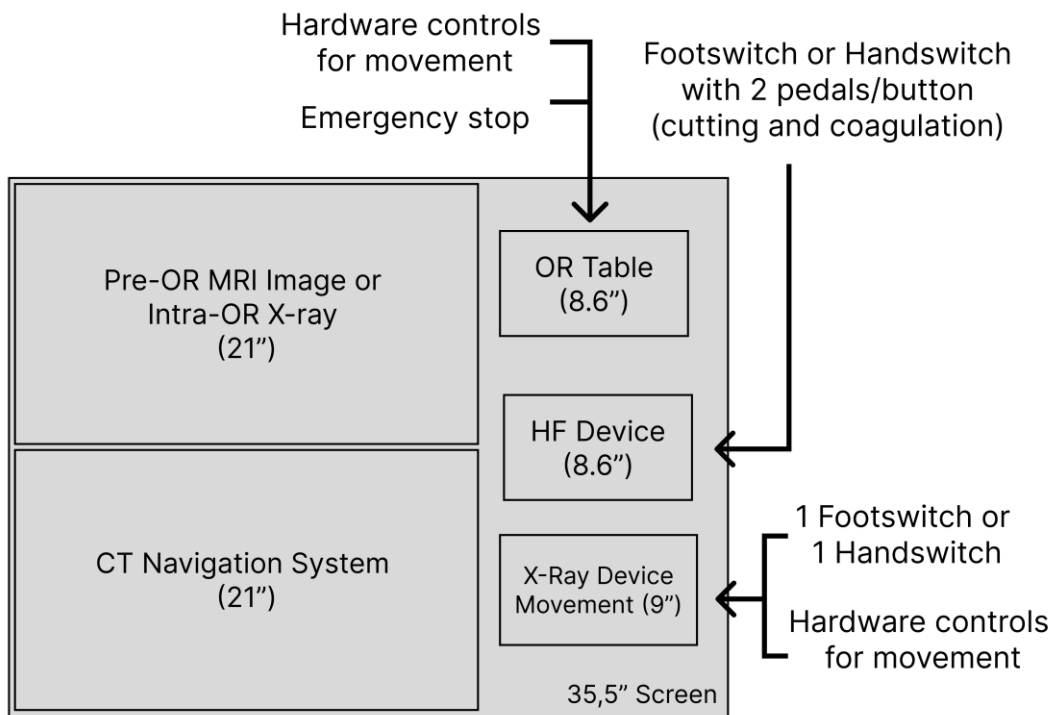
Proposed workstation solution consisting of Screens for the navigation system, MRI Screen, OR table, HF Device, and X-Ray device.
